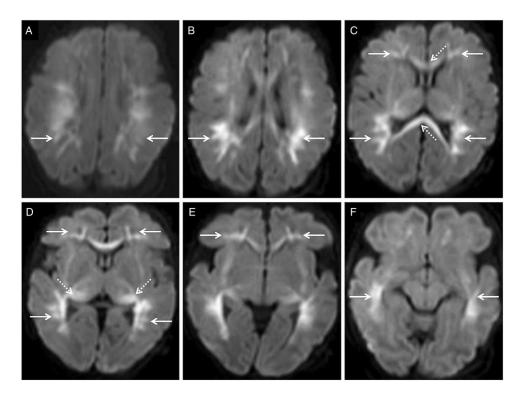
Parechoviral infection in a neonate presenting with fever and seizures. Diffusion-weighted imaging (DWI; A-F) reveals near symmetric restricted diffusion (ADC not shown) extensively involving the cerebral white matter bilaterally. Note the linear, radiating pattern of the signal abnormality (arrows) towards the subcortical and juxta-cortical white matter. Restricted diffusion is also noted in the corpus callosum (dotted arrows in C) and the dorso-lateral thalami (dotted arrows in D), suggestive of preWallerian degeneration ADC = apparent diffusion coefficient.
